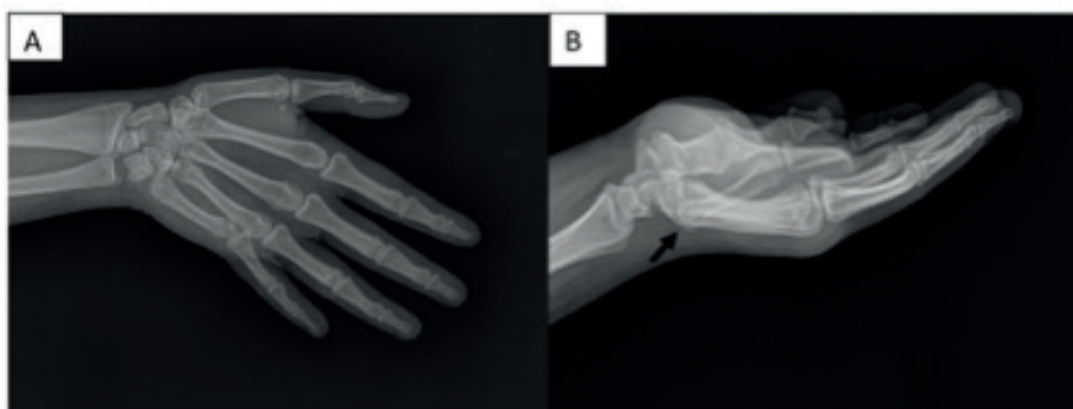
A) AP and B) lateral radiographs of the first arrival at the hospital, arrow; undiagnosed 5th CMC joint dislocation.
